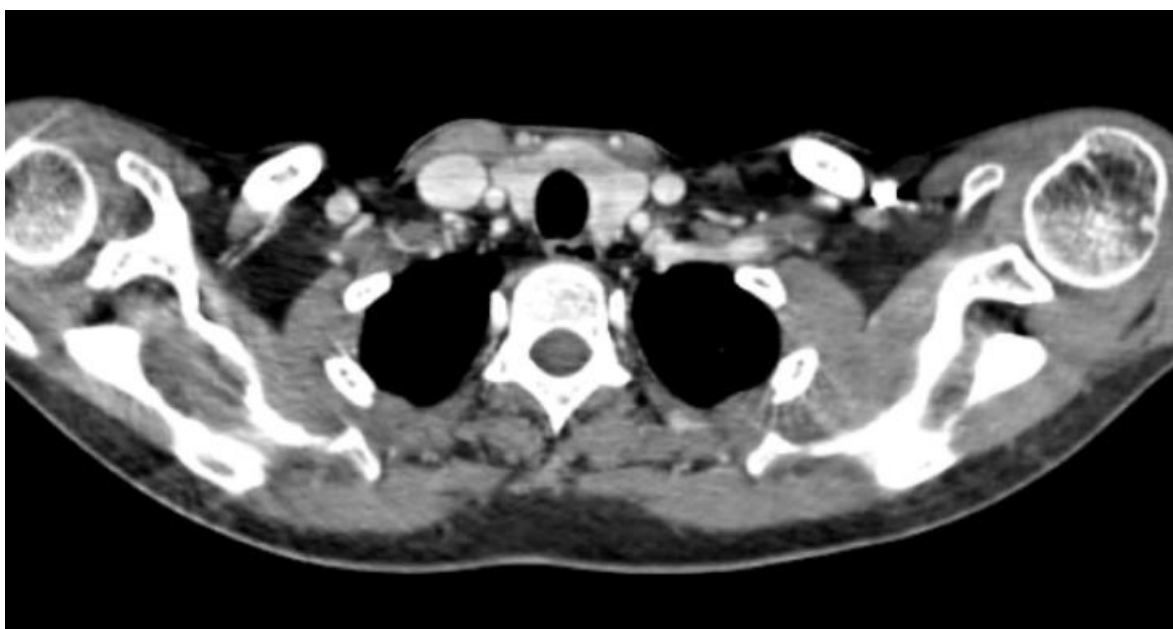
Abdominal CT showing an oesophageal thickening.
